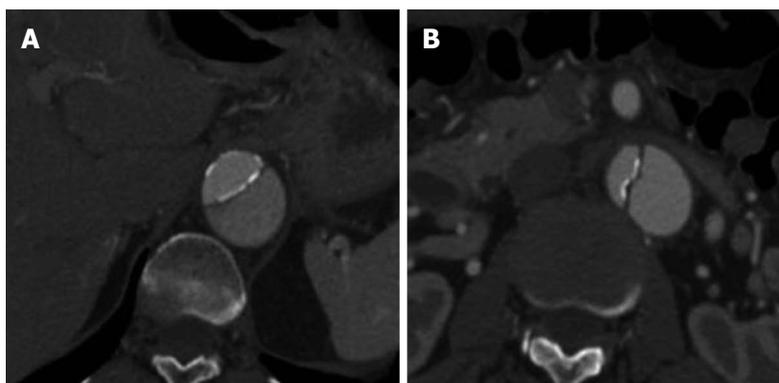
A 59-year-old lady with a type B aortic dissection. Axial images from a computed tomography aortogram show atherosclerotic calcifications outlining the true lumen at the lower thoracic aorta (A). The true lumen is of smaller calibre and shows early and more intense enhancement than the false lumen at this level. More inferiorly at the level of the left renal vein (B), eccentric intimal-medial flap calcification (note the calcification along the true luminal aspect of the flap) is exquisitely demonstrated.
